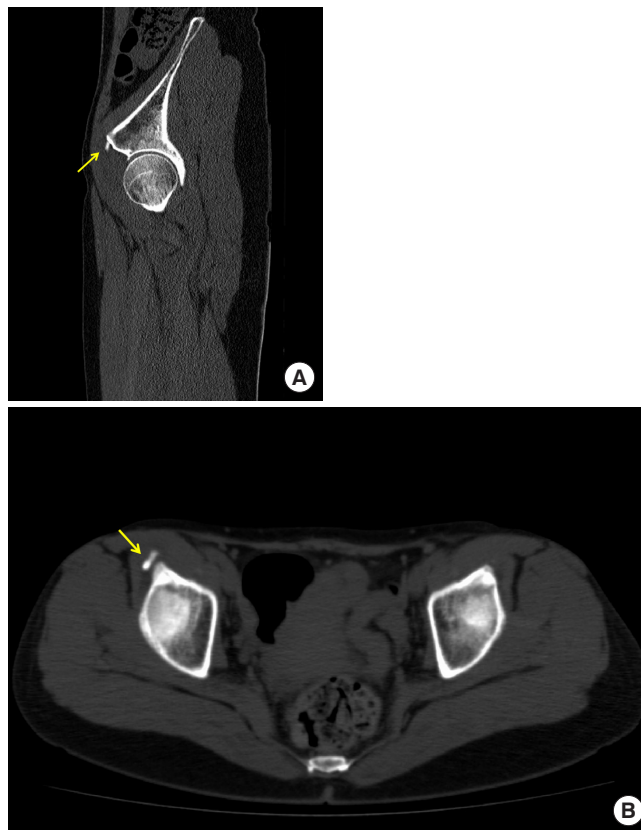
Computed tomography showed calcific deposits within the direct head of the right rectus femoris (arrows) on (A) sagittal and (B) axial view.
